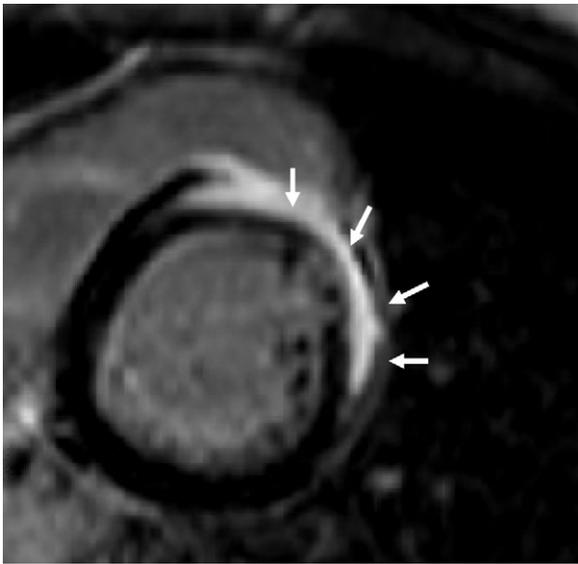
Delayed enhancement on cardiac magnetic resonance imaging (MRI) in a cardiac sarcoidosis (CS) patient. Evidence of delayed gadolinium enhancement on cardiac MRI in the sub-epicardial layer of the anterior left ventricular wall (multiple small white arrows) in a 41-year-old male patient with sustained ventricular tachycardia and diagnosed with CS on the background of a pre-existing pulmonary sarcoidosis.
